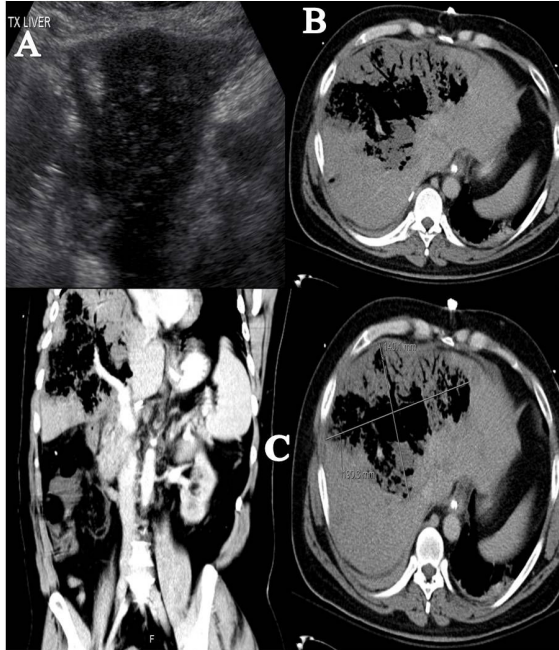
(Pannel A) Doppler ultrasonography reveal extensive intrahepatic gas. (Pannel B&C) Computed tomography of the abdomen and pelvis reveal an extensive area of hepatic necrosis with abscess formation measuring 19x14 cm with extension of gas into the peripheral portal vein branches.
